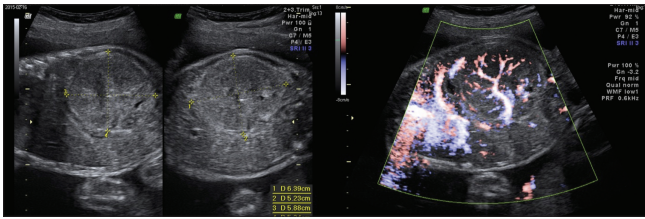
The prenatal ultrasound at 32 weeks of gestation showed one well-circumscribed, solid, and low-level homogeneous echoes mass with abundant flow in the left kidney, measuring 6.0 cm × 5.8 cm × 5.2 cm in size, associated with polyhydramnios
